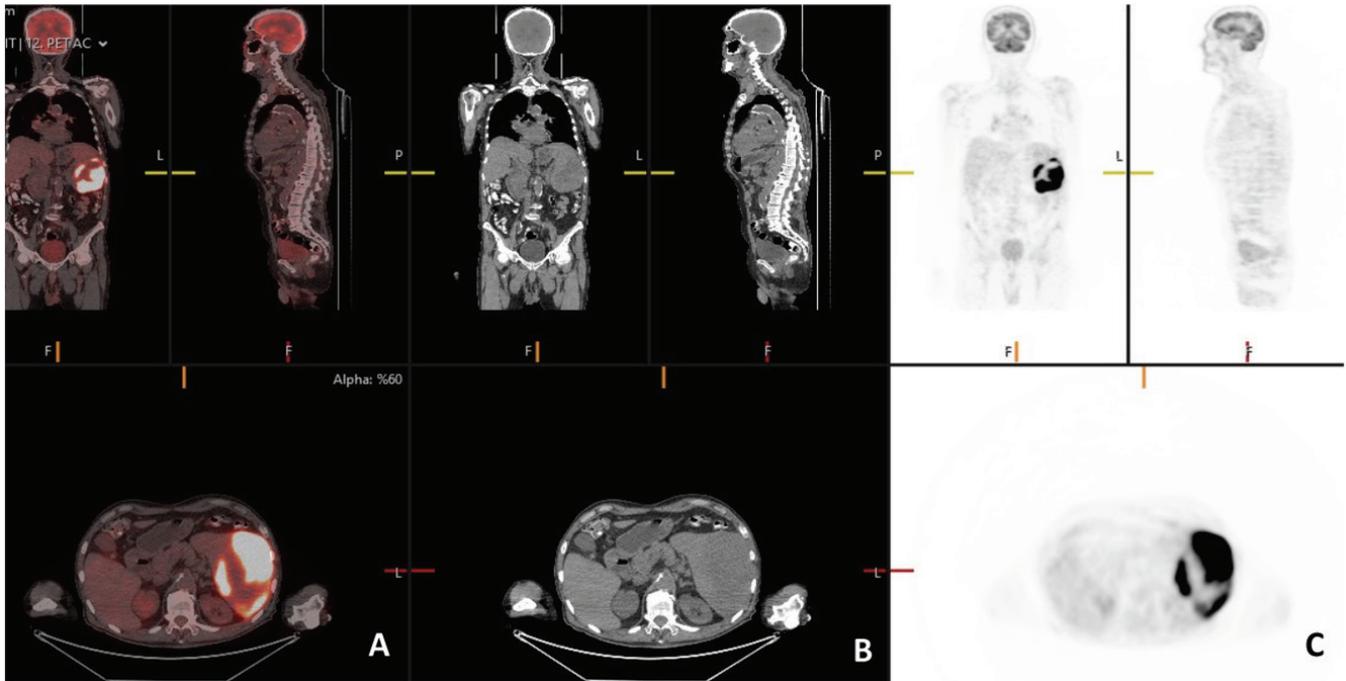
PET/CT (A), CT (B), and 18F-FDG PET/CT (C) scans show increased uptake localized to the enlarged spleen ($SUV_{max} = 36.9$), findings consistent with lymphoma.
